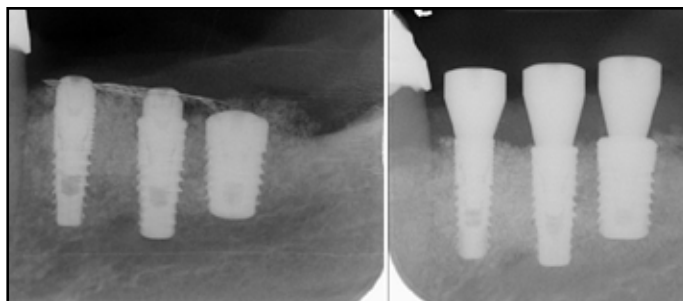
A postoperative periapical radiograph (left) and radiograph (right) after uncovering on the right site.
